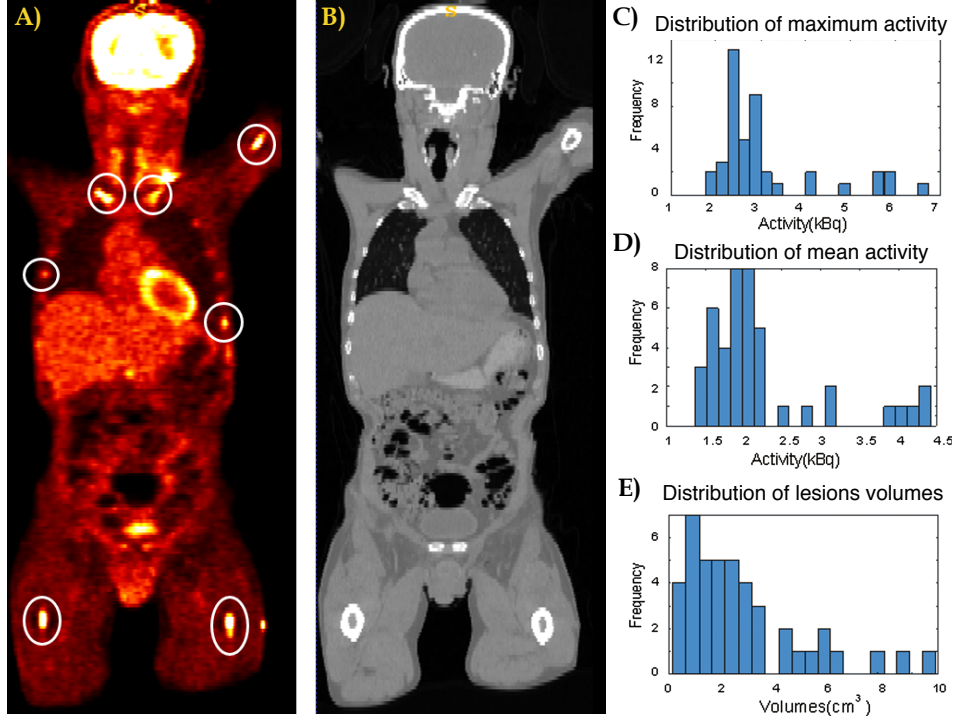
A distribution of MM lesions within a patient with ^{68}Ga -Pentixafor PET/CT imaging: A) ^{68}Ga -Pentixafor PET scan. The MM lesions are indicated by the white circles. B) The corresponding CT scan. The distribution of the lesions maximum uptake values C), mean values D) and volumes E).
